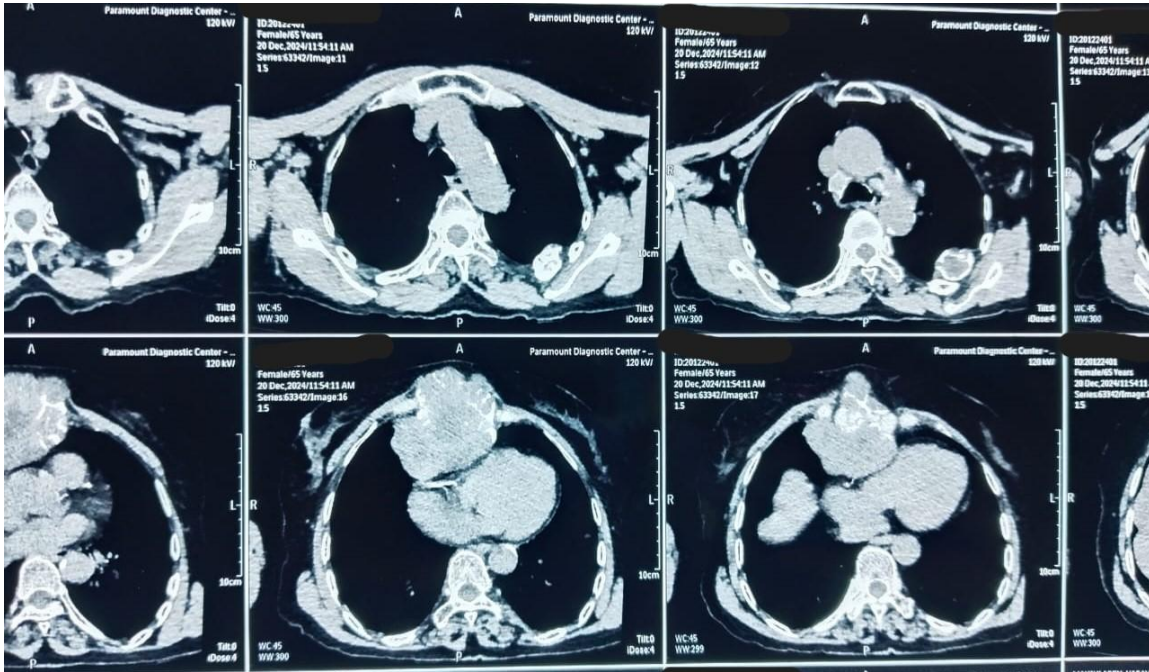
Computed Tomography with contrast of Chest
